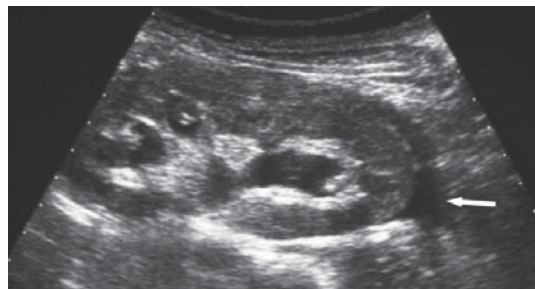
Ultrasonography. Urinoma (patient with left renal colic). Left kidney with dilated pelvis and calices associated with a subcapsular fluid collection at the level of the lower pole attributable to urinoma (*arrow*)
